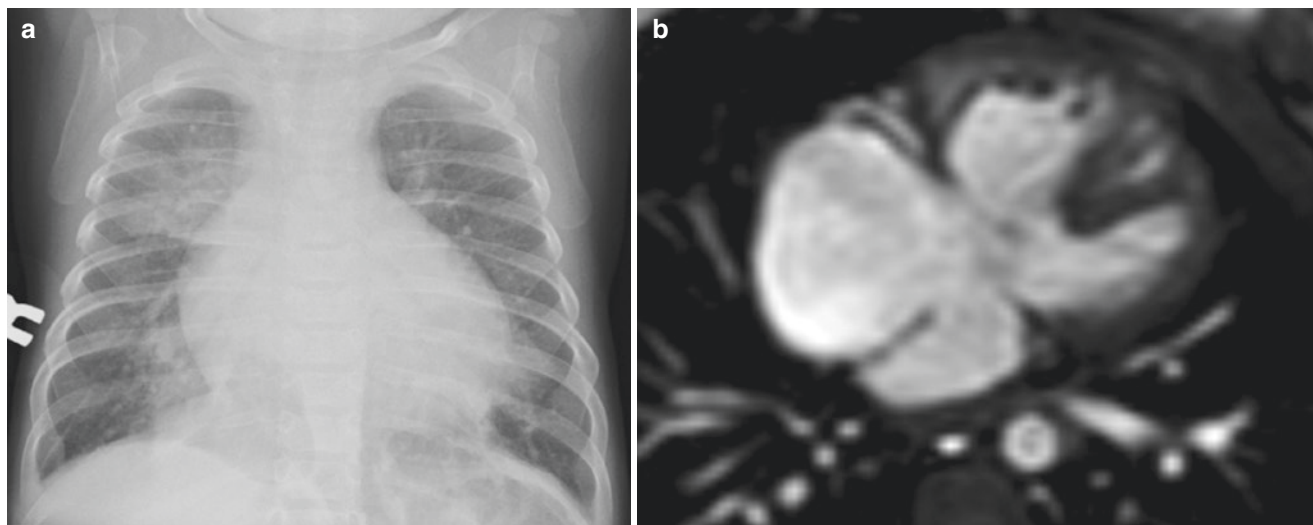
A newborn girl with pulmonary hypertension secondary to atrioventricular defect. (a) Frontal chest radiograph shows increased pulmonary vascularity and cardiomegaly. (b) Axial T1 MR image demonstrates an atrioventricular septal defect
